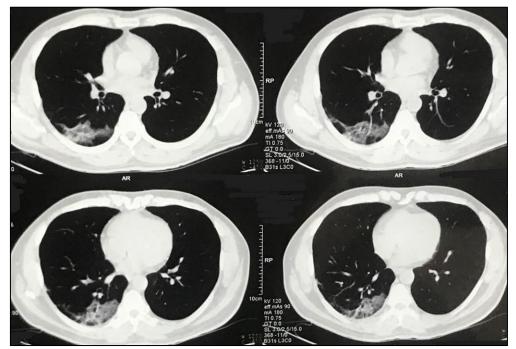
HRCT thorax showing pleural based consolidation in right lower lobe with lines and parenchymal bands with normal left lung
